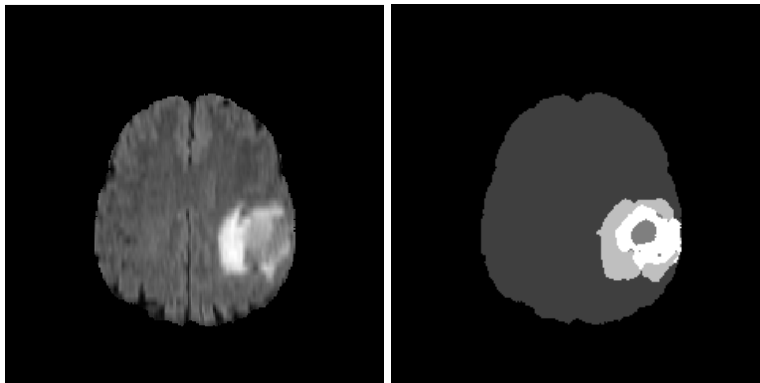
MRI with its corresponding segmentation
